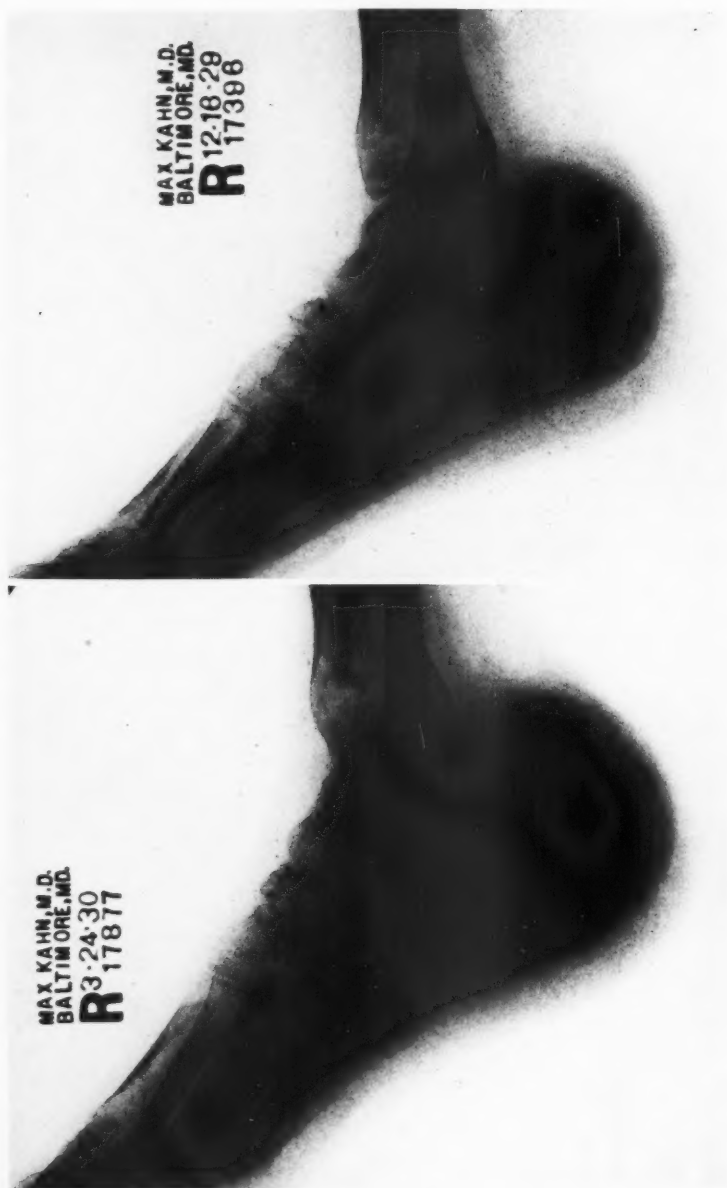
E (above). Roentgenogram showing the os calcis eighteen months after the injury. Patient had just completed two months of intensive deep X-ray therapy. The growth was not checked and the entire posterior two-thirds of the calcaneum is now destroyed. Some trabeculation is present along the plantar surface and probably represents a reaction to the X-ray therapy. Same case as shown in Figures 6-A, 6-B, 6-C, and 6-D.
